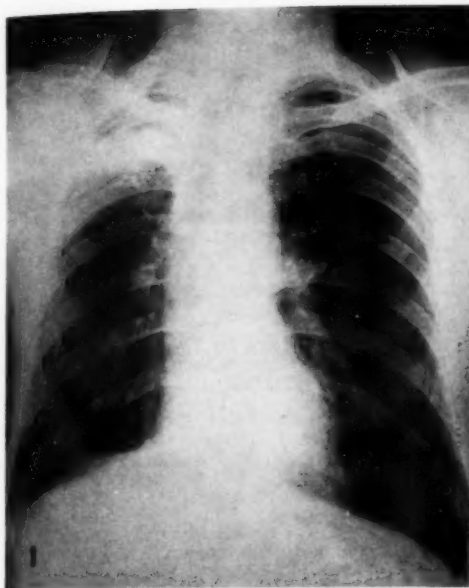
Plain postero-anterior roentgenogram of the chest. The cavity in the right upper lobe is visible but the mass is not demonstrated.
